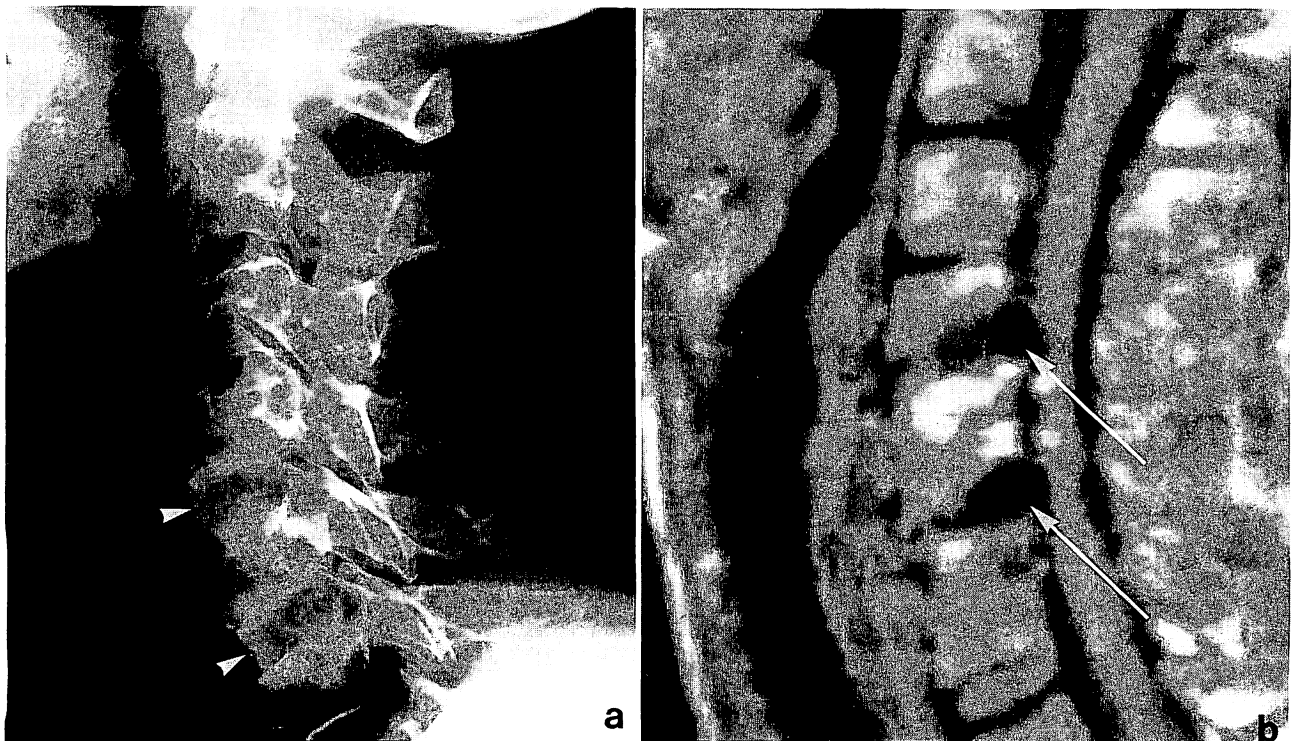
Metallic artifact (small metal particles). A 54-year-old female with cervical spondylosis. The posterior spurs were removed via the anterolateral approach using a diamond drill, with iliac bone grafts at C4/5 and 5/6 levels. a) A lateral cervical film. Arrowheads indicate grafted iliac bones. b) T1-weighted SE image. Local image (arrows) is obscured by small metal particles, remnants of operative procedures
